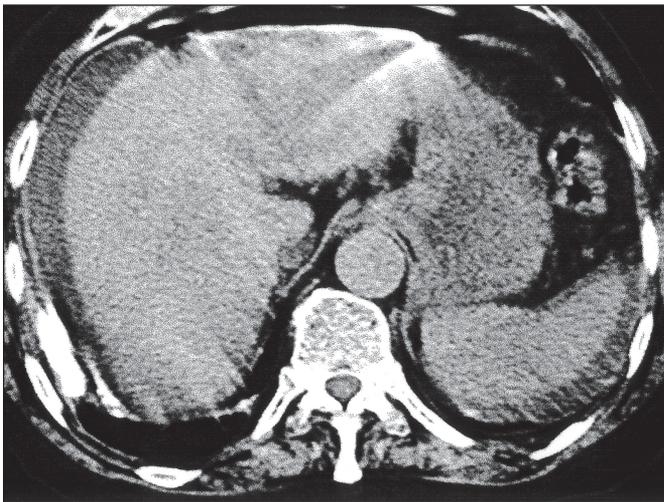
CT scan confirmed the presence of free intraperitoneal air, showing subdiaphragmatic effusion.
